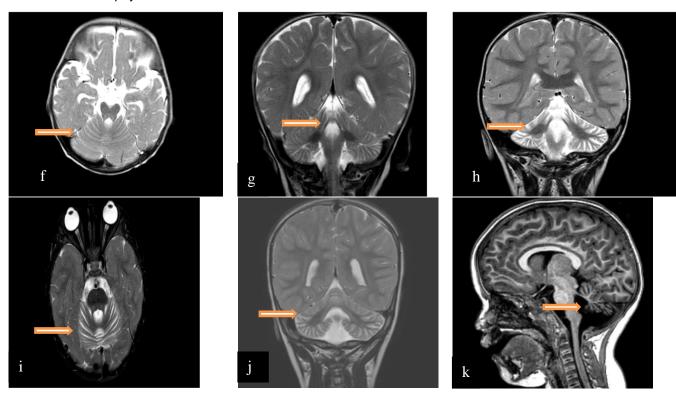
Brain MRI of the patients. (a) is the T2 sagittal section of patient 1, which shows cerebellar atrophy. (b) and (c) show the coronal and axial sections of patient 2, respectively, demonstrating severe cerebellar atrophy. (d) and (e) show the sagittal and coronal sections of patient 3, which show mild cerebellar atrophy.
